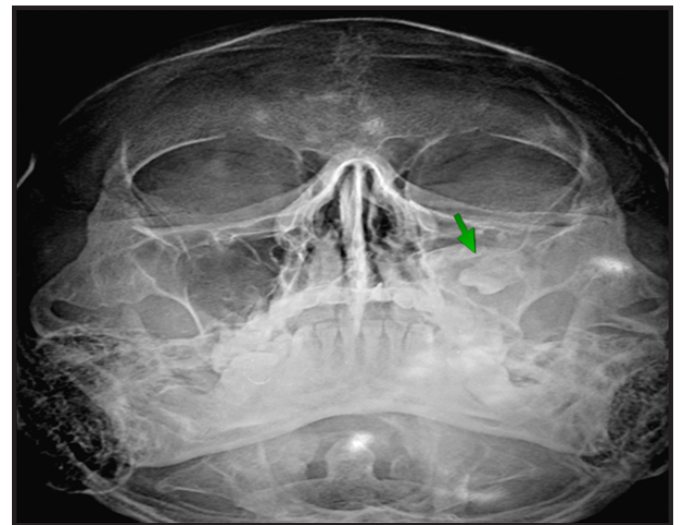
Para nasal sinus view radiograph showing unerupted tooth in the left maxillary sinus surrounded by a discrete opaque mass (arrow).
